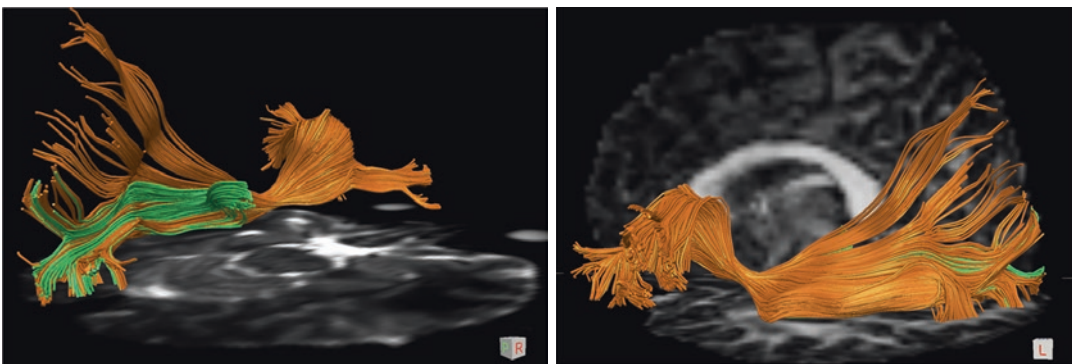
Medial (upper panel) and lateral (lower panel) views of the left IFOF (orange) and OR (green) displayed over FA map and T2-weighted MRI, respectively. The OR streamlines are intermingled with those of the posterior third of the IFOF and both course along the most medial and ventral part of the temporo-parietal fiber intersection area (TPFIA). The IFOF and the OR are the most eloquent
